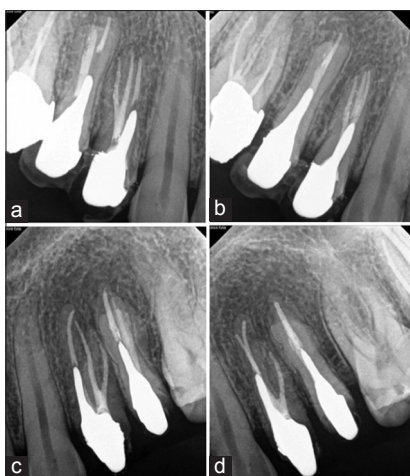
(a and b) 1-year recall periapical radiograph of the maxillary right first premolar. (c and d) 1-year recall periapical radiograph of the maxillary left first premolar
